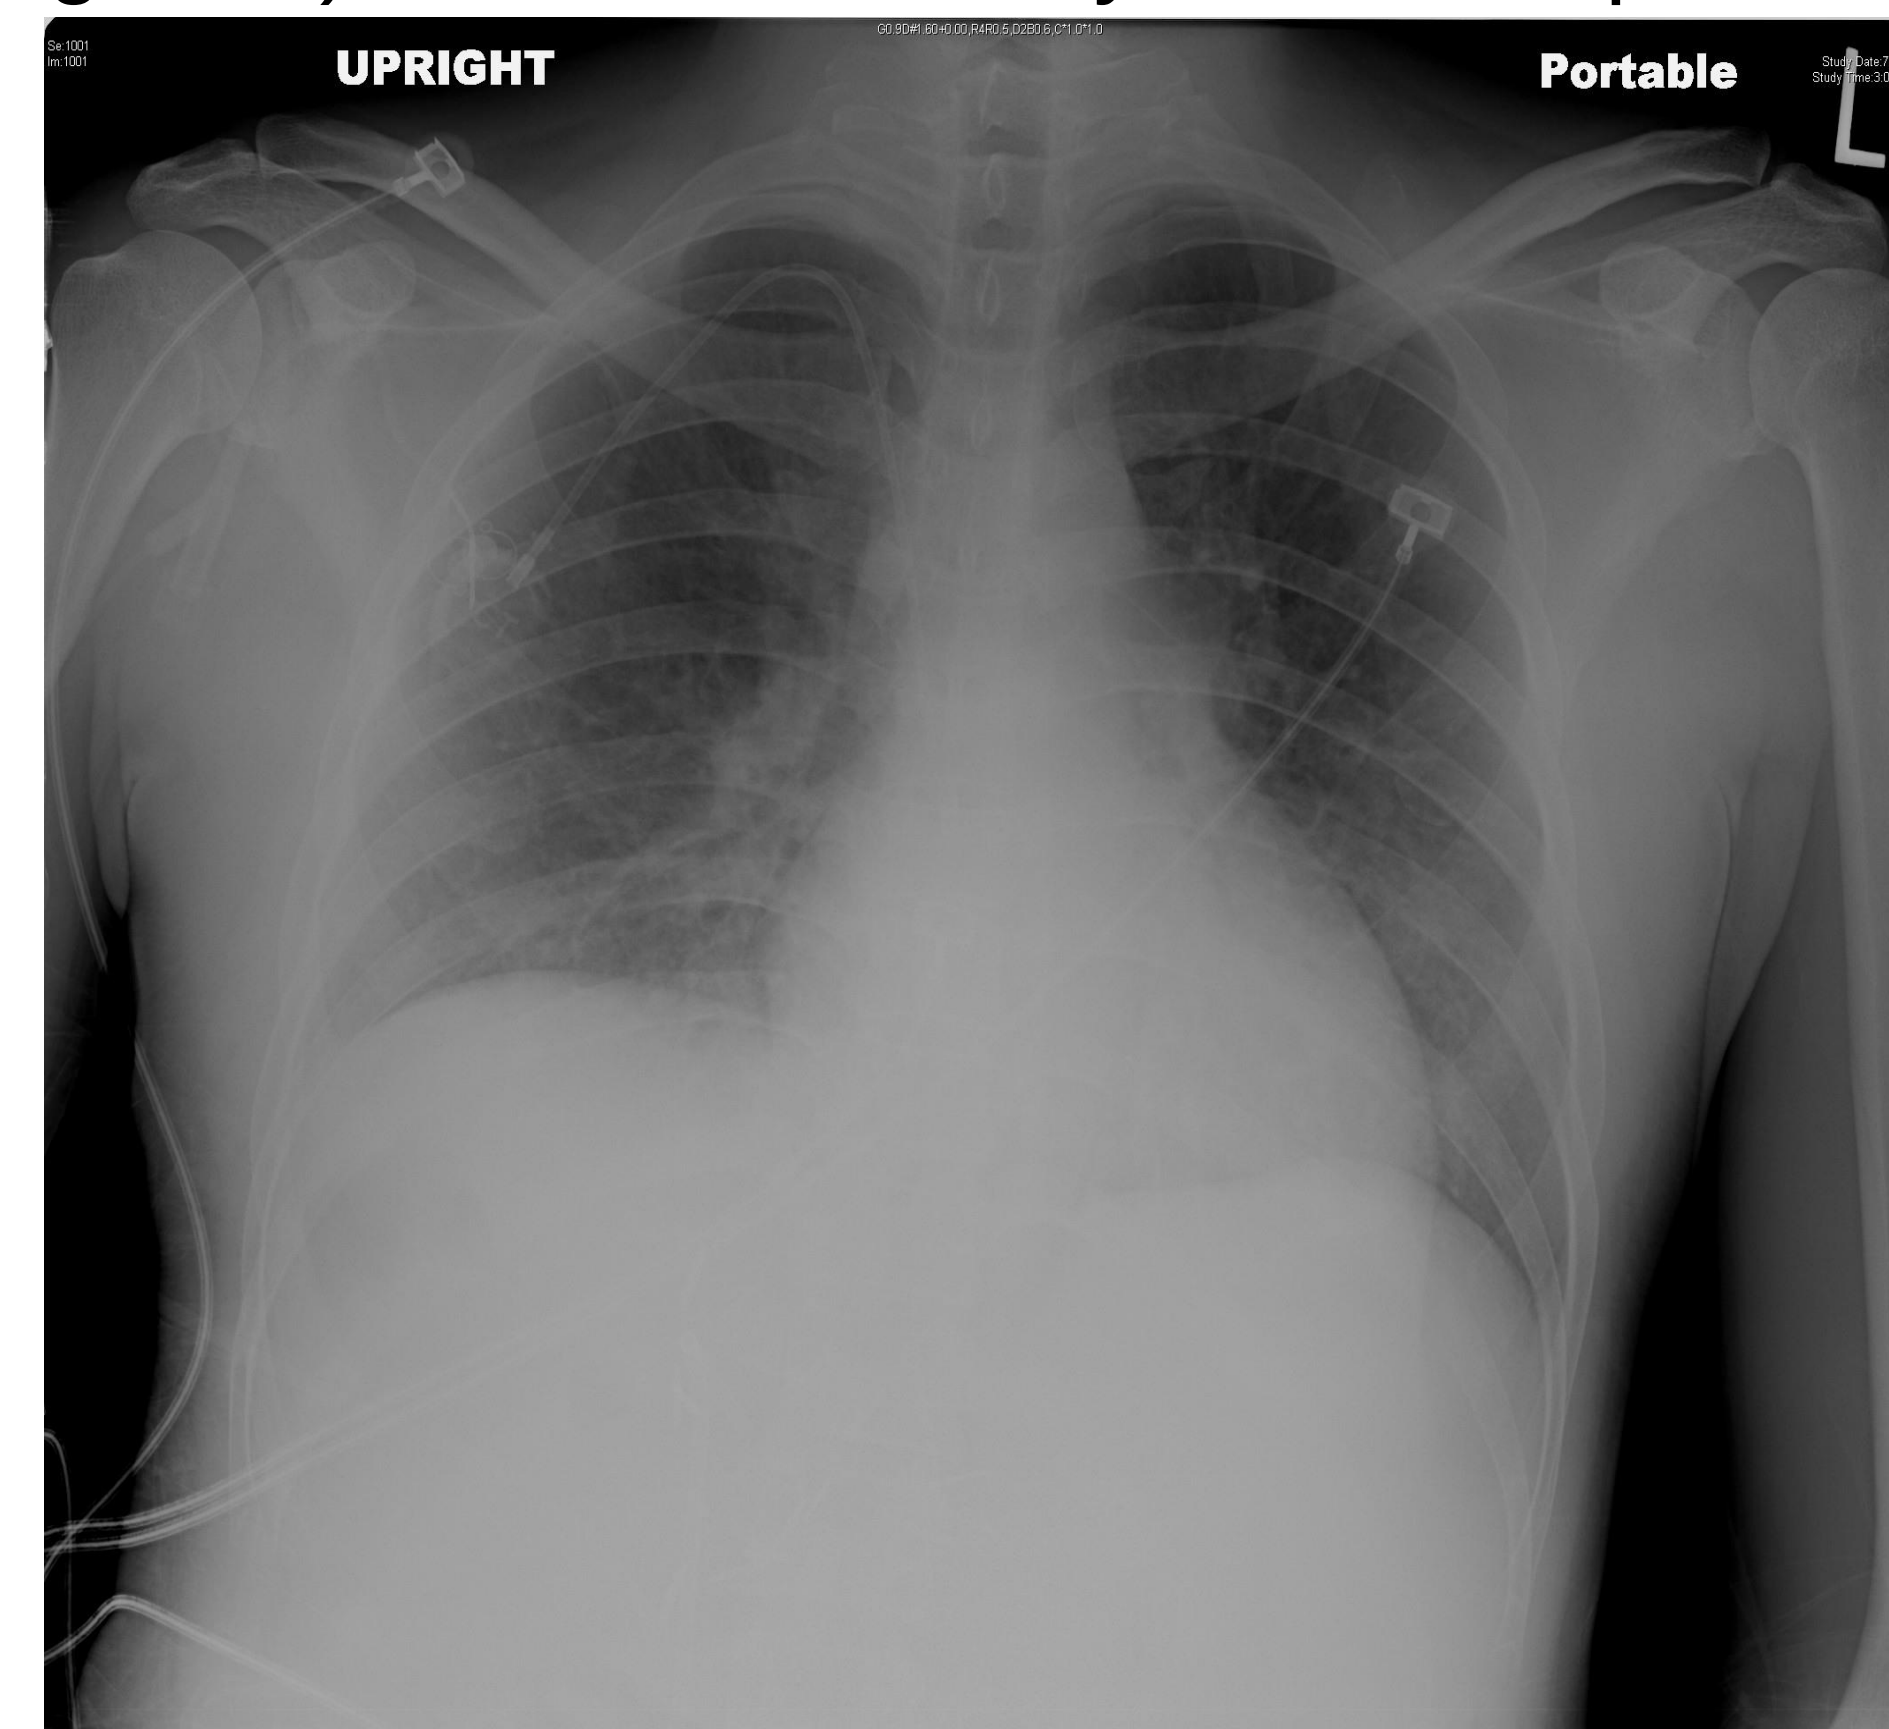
Chest radiograph of patient at time of admission. Lung fields are clear with normal vascular markings.
